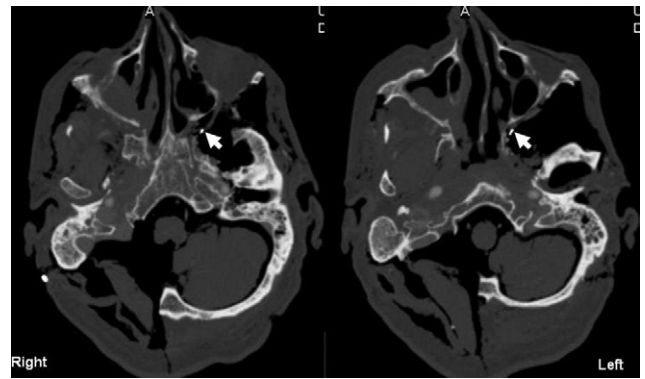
Axial computed tomography cuts through the region of the sphenopalatine ganglion. The right side of each image was not dissected. The left side of each image was dissected and a radiopaque marker placed in the pterygopalatine fossa to mark the position of the sphenopalatine ganglion (arrows).
